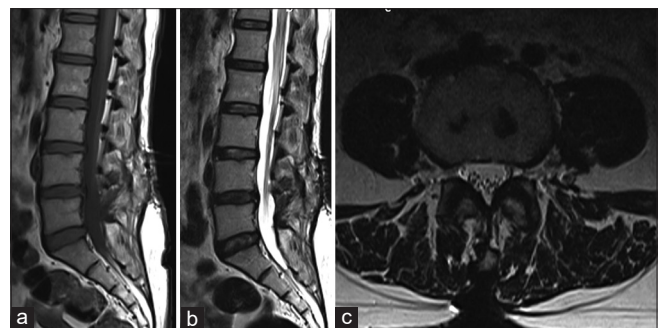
Magnetic resonance imaging of the patient showing complete resolution of pseudomeningocele at 1-year follow-up. Sagittal T1-weighted (a), Sagittal T2-weighted (b), Axial T2-weighted (c)
